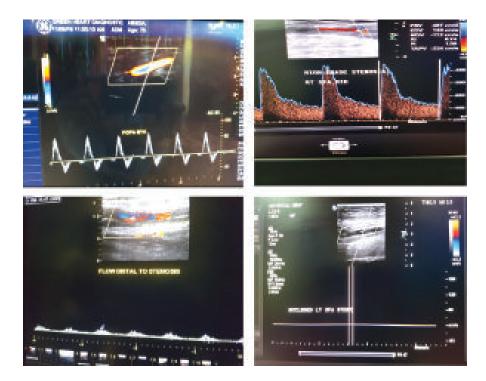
A. Normal triphasic arterial flow. B. Turbulence with velocity acceleration at the point of arterial stenosis. C. Dampened low pulsatile monophasic flow distal to arterial stenosis. D. Totally occluded artery with absence of Doppler signal
